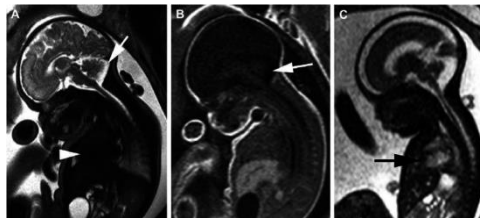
Model of fetal MRI
